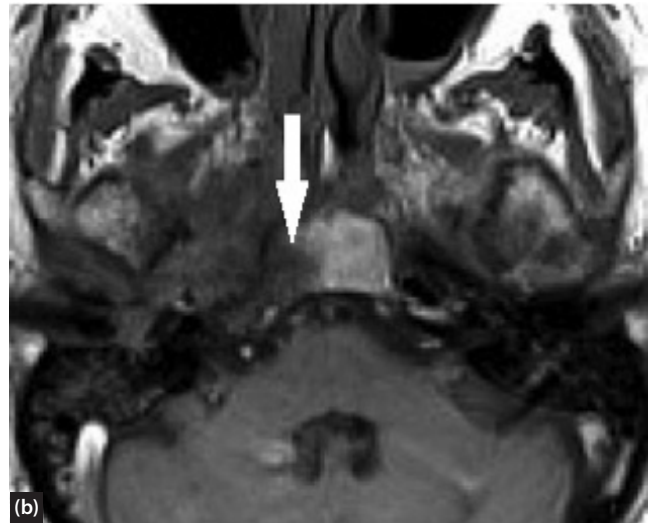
Axial CT (a) and T1 weighted MRI without fat suppression (b) in patient with right NOE. Normal bone cortex is preserved on CT, but T1 MRI shows early marrow infiltration and loss of normal fatty marrow signal (arrow) in keeping with early central skull base osteomyelitis.
